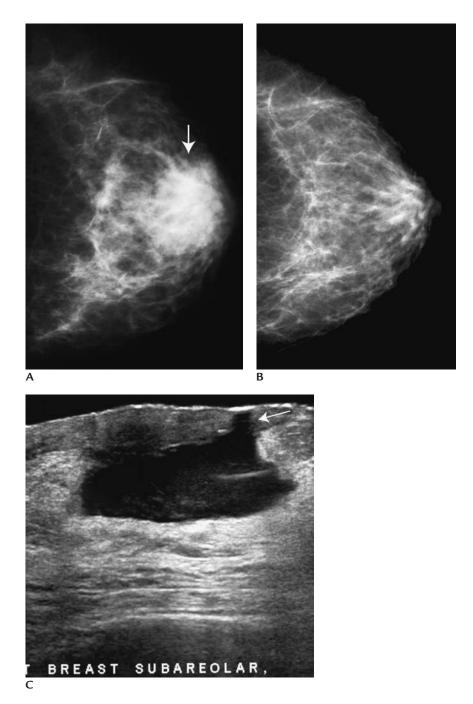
Subareolar abscess. (A) Oval mass (*arrow*) with indistinct and obscured margins in the left subareolar area corresponding to a tender "lump" with associated erythematous skin changes. (B) Prior left craniocaudal view for comparison demonstrating normal subareolar area. (C) Sonographically, a nearly anechoic, oval mass with associated posterior acoustic enhancement is present in the left subareolar area corresponding to the clinical and mammographic finding. Secondary involvement of the skin and skin thickening are present and a common finding in patients with subareolar abscesses. Spontaneous fistula formation (Zuska's disease) in the periareolar region is common in these patients. A fistula is close to forming in this patient as evidenced by the close proximity to the superficial dermal layer of a portion of the abscess (*arrow*).
